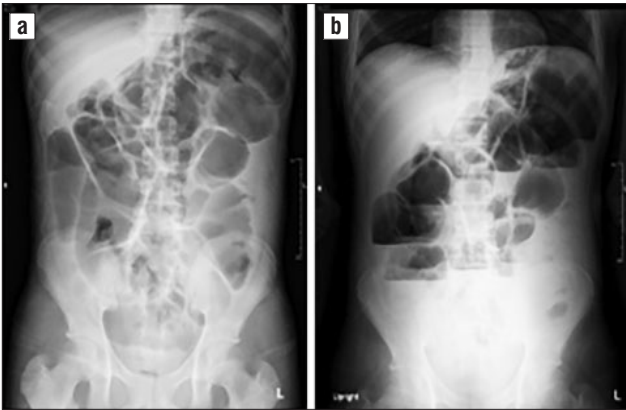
Follow-up Abdominal X-ray
